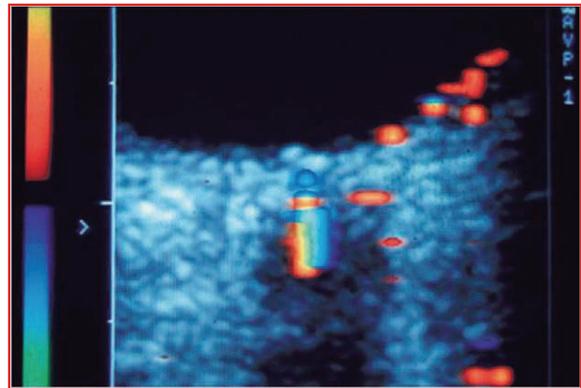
Cross sectional ultrasonogram through the posterior pole of the eye, color-coded signals from central retinal artery (red) and central retinal vein (blue) are displayed inside the distal optic nerve.
